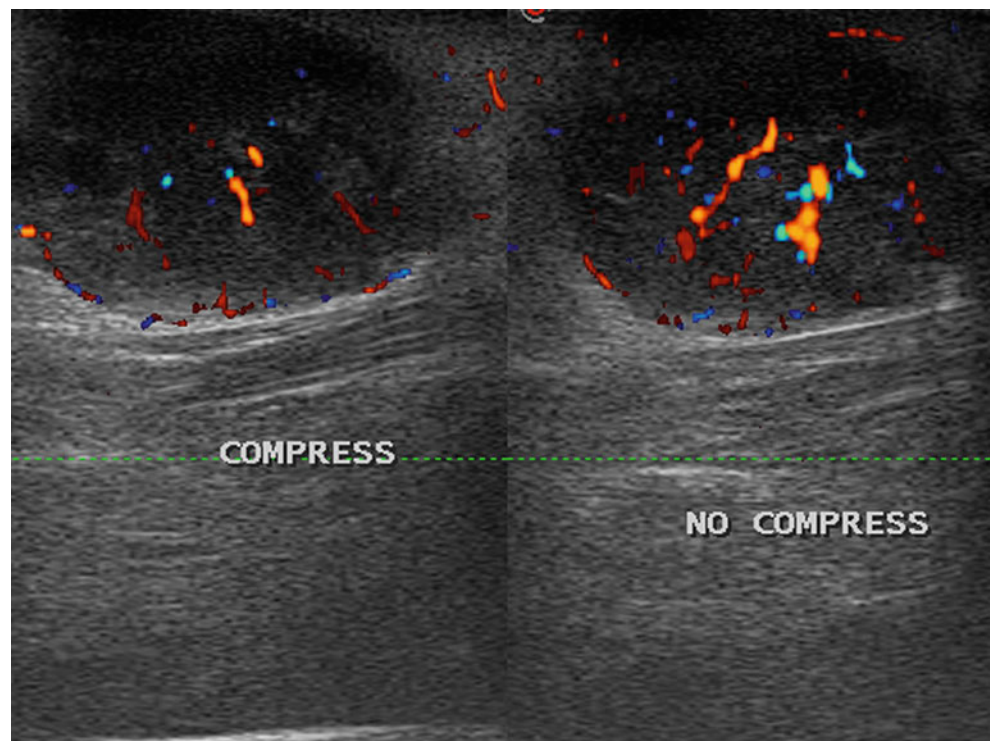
Ankle melanoma metastasis. Directional power Doppler image with and without (intentional) compression. Attention should be paid to avoiding excessive compression with the transducer that can consistently attenuate the flow signals
